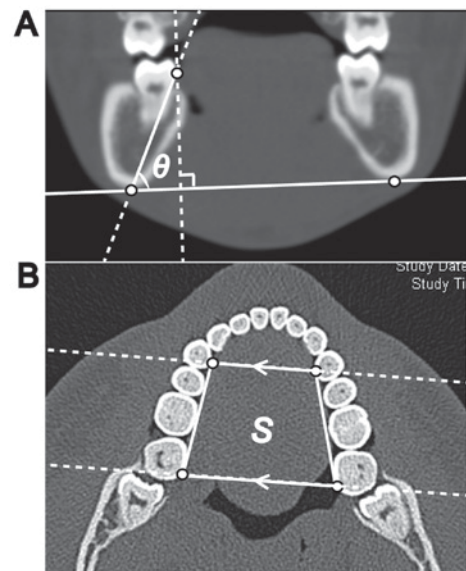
Measurement methods for the θ and S values. (A) The position of the mandibular second molar on the affected side is represented by the angle θ , formed against the straight line connecting two tangential points along the inferior borders of the bilateral mandibular bone. The lingual contact point on the mandibular second molar is present on the line perpendicular to the inferior border of the bilateral mandibular bone on coronal CT images. Each data point is obtained through measurements taken from the same coronal CT image. (B) S represents the area of the trapezoid, formed by the lingual edges of the bilateral posterior corners of the mandibular second molars and the center of the lingual side of the first premolars on axial CT images. The two vertices on the first premolars are the intersection points of a line parallel to the lower line along the two lingual edges of the bilateral posterior corners of the mandibular second molars, which passes through the center of the lingual side of the bilateral first premolars. The slice height on the axial CT images was determined as being half of the crown height of the bilateral mandibular second molars. CT, computed tomography.
